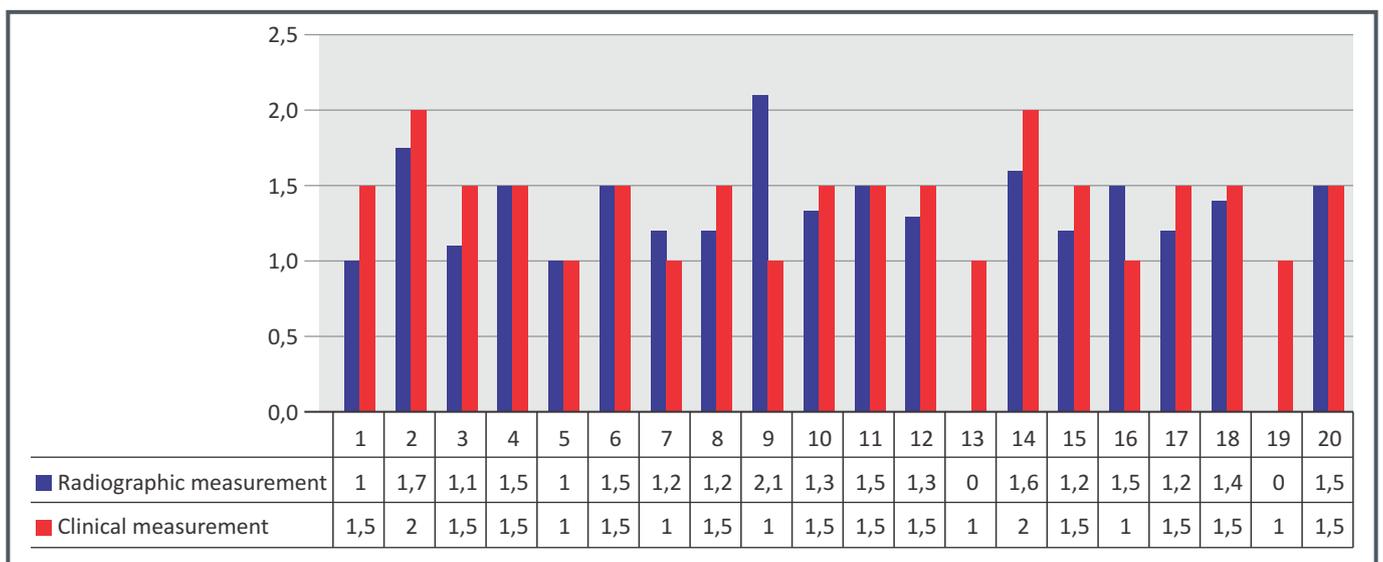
The values of clinical depth of caries lesion measured by graduated probe, and the values obtained by measuring the area of radiolucent zone corresponding to the carious lesion on radiographs using ImageJ, in molars of total sample
